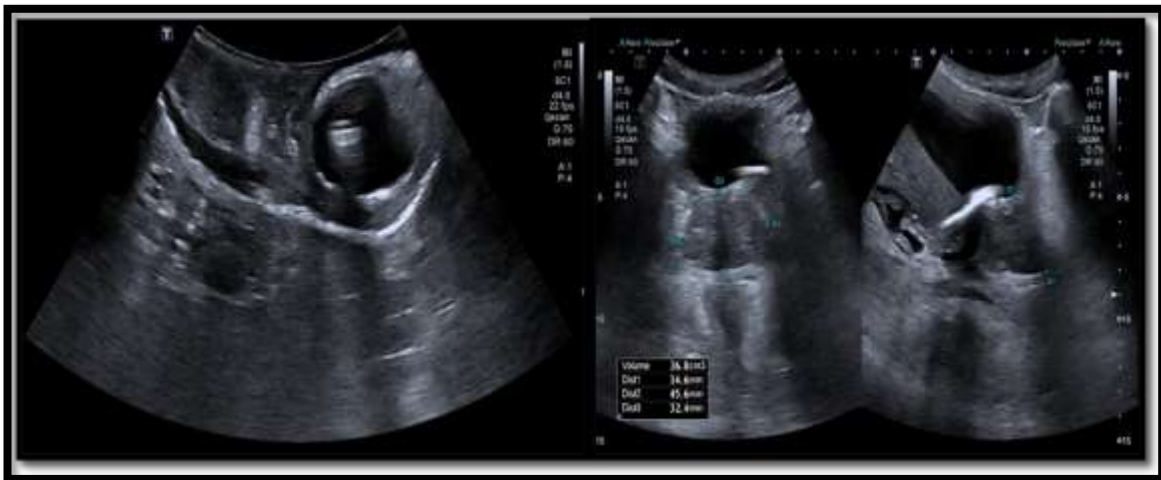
Imaging Findings from Scrotal Ultrasound(Ballon of foley catheter within left scrotum)
